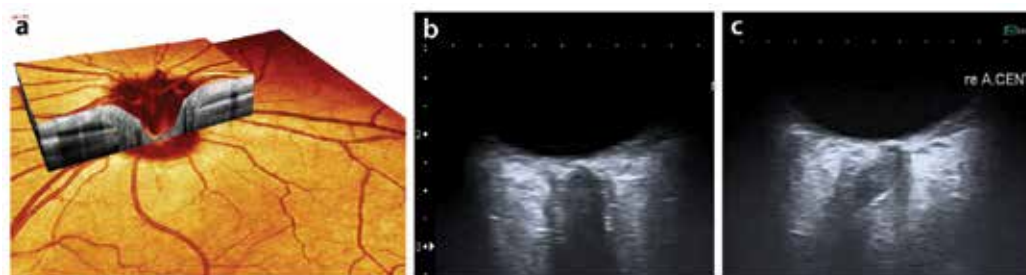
Anatomical landmarks for ultrasound examination (a) Ocular coherence tomography (Spectralis®, Heidelberg Engineering, Germany) excellently demonstrating the retinal vasculature and layers of the retina. However, inlay demonstrates limited penetration beyond the level of the retina. (b) High resolution B-mode sonography in the horizontal and lateral scanning plane presenting the optic nerve as a hypoechogenic structure beyond the retina surrounded by the hyperechoic subarachnoid space and the hypoechoic dura mater. The optic nerve provides an anatomical landmark for the ultrasound examination. For anatomical correlates see Figure 3. (c) In a strictly axial horizontal image plane, the optic nerve appears curved limiting the diagnostic accuracy of optic nerve diameter measurements
